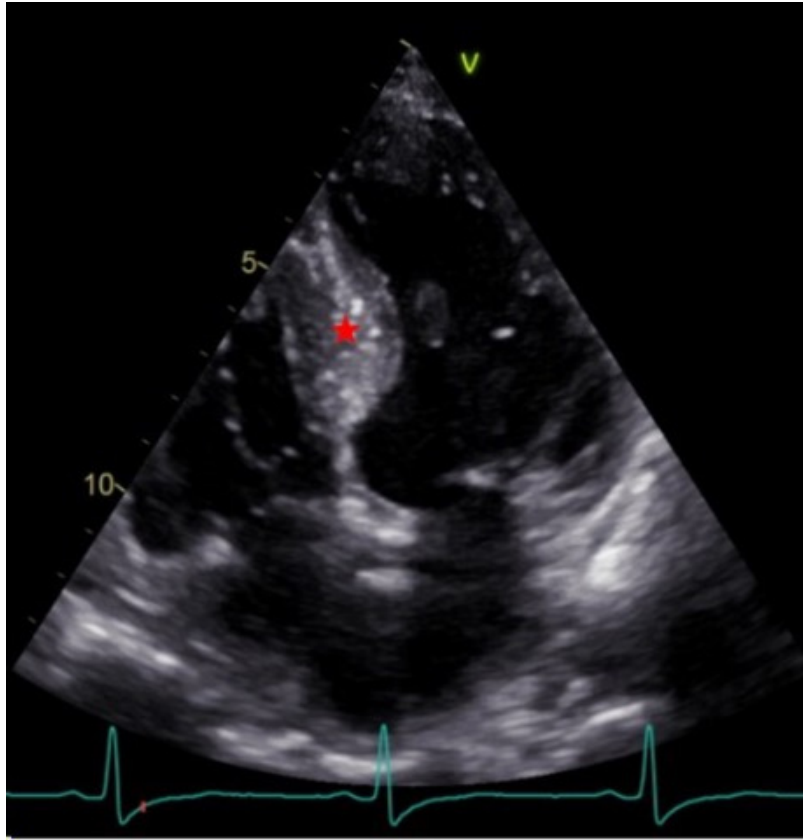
Parasternal uzun aks. Kirmızı yıldız: Septal hipertrofi
